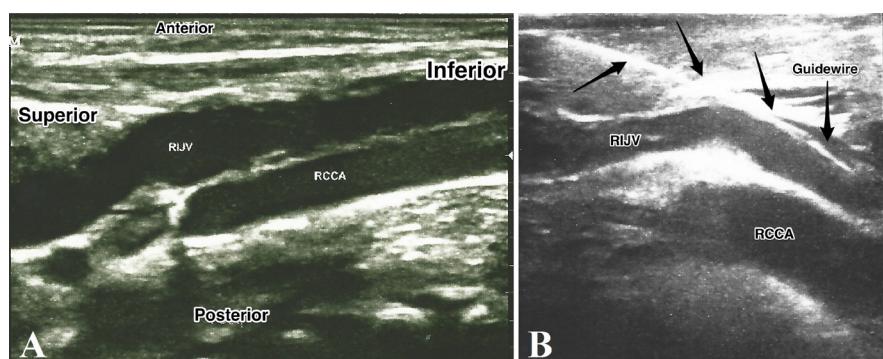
A: ultrasonographic image of the right internal jugular vein and common carotid artery on the longitudinal plane. B: ultrasonographic image of the guidewire in the right internal jugular vein on the longitudinal plane
